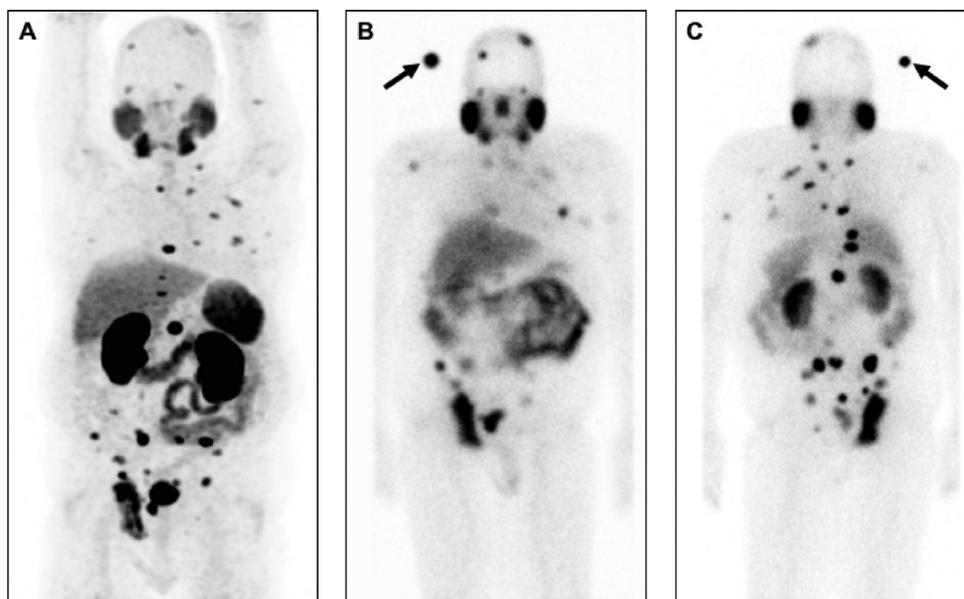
Theranostic pair of ^{68}Ga -PSMA PET/CT scan followed by therapeutic ^{177}Lu -PSMA therapy. (A) ^{68}Ga -PSMA PET (MIP) demonstrating extensive bony metastatic prostate carcinoma. (B) Anterior projection: ^{177}Lu -PSMA post-treatment scan 24 hours after administration demonstrating excellent localization of ^{177}Lu -PSMA to site of ^{68}Ga -PSMA avid disease. (C) Posterior projection of ^{177}Lu -PSMA post-treatment scan.
